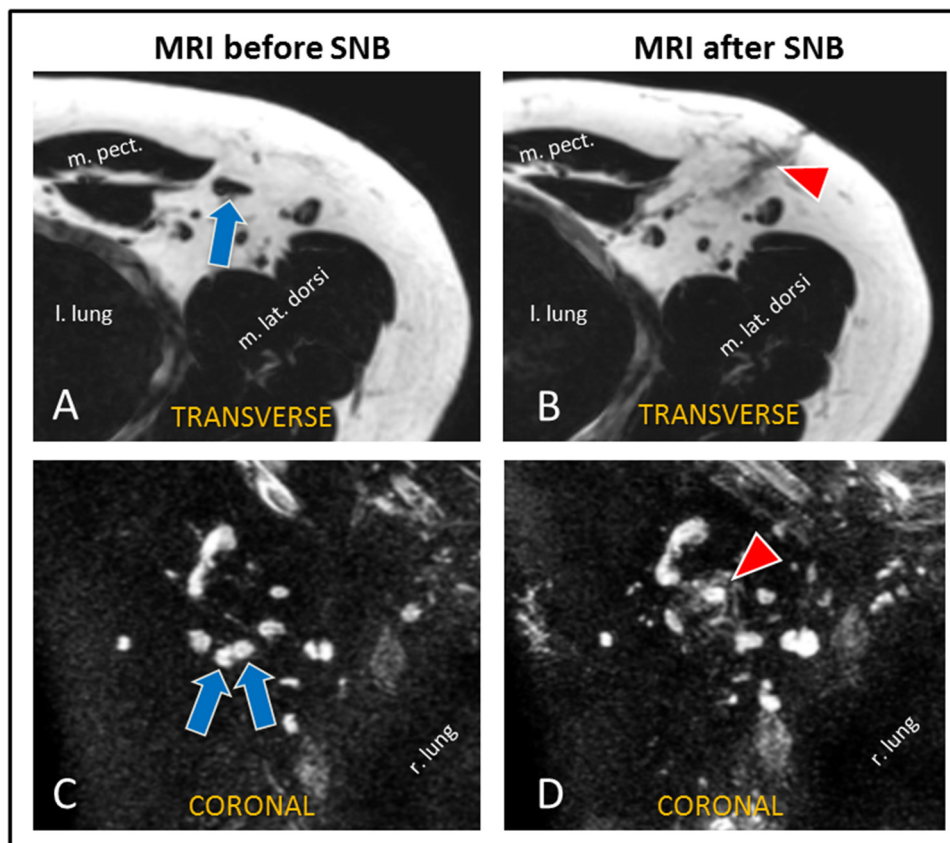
Axillary LNs visualized with MRI before and after SNB. MR images from before SNB (left, (A) and (C)) and after SNB (right, (B) and (D)), in two patients (each row) are depicted. The first row shows Dixon-fat images of a transverse T1-TFE, (A) and (B), where the arrow points to the SN (i.e. absence of fat signal in the SN); the right arrowhead points to postoperative anatomical changes, e.g. presence of seroma. The second example, (C) and (D), is a T2-TSE coronal scan. The blue arrows and red arrowhead similarly show two SNs and postoperative seroma, respectively. *Abbreviations:* SNB = sentinel-node biopsy; m. pect = musculus pectoralis; r. lung = right lung; m. lat. dorsi = latissimus dorsi muscle; l. lung = left lung; T1-TFE = T1-weighted turbo field echo; T2-TSE = T2-weighted turbo spin echo.
